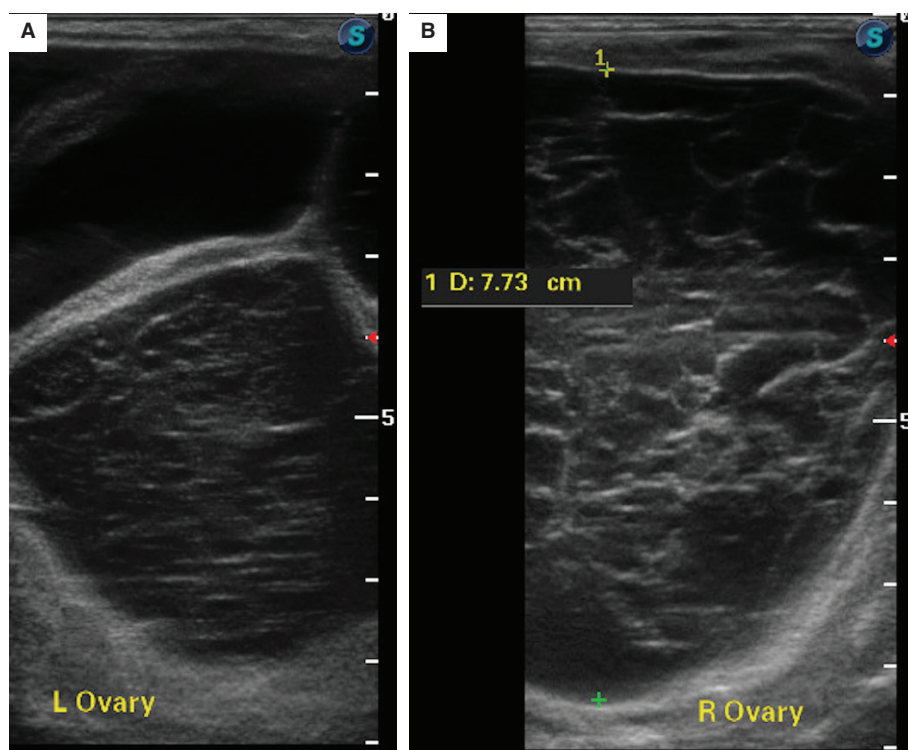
Transrectal ultrasonographic images of ovaries on initial presentation. (A) Left ovary (note multiple large follicular like structures and fibrin strands). (B) Right ovary (note a 7.7 cm structure [echotexture resembling corpus hemorrhagicum, hematoma, or hemorrhagic anovulatory follicle] and fibrin strands)
